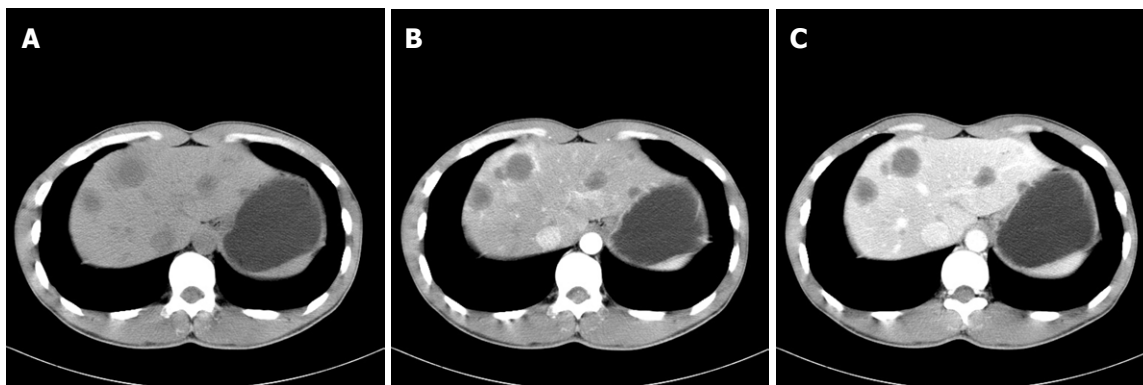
Multifocal hepatic epithelioid hemangioendothelioma in a 27-year-old male. (A) Unenhanced axial computed tomography scan of liver shows multiple discrete masses, which are round with a low density and peripheral iso-density. (B-C) Partial lesions show peripheral ring-like enhancement in the arterial phase (B) with even stronger enhancement in the portal venous phase (C).
